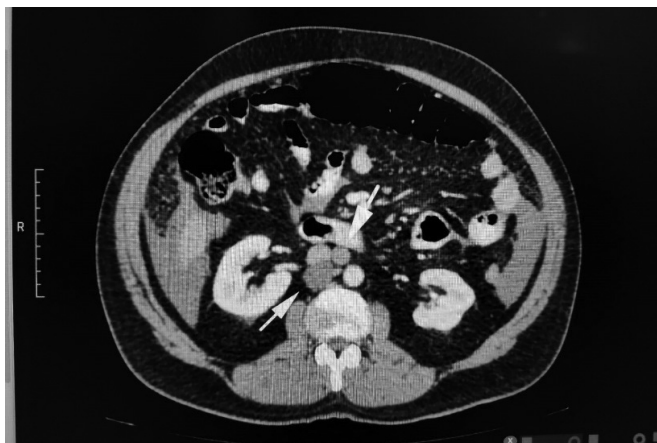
CT scan axial section showing large metastatic lymph nodes.
